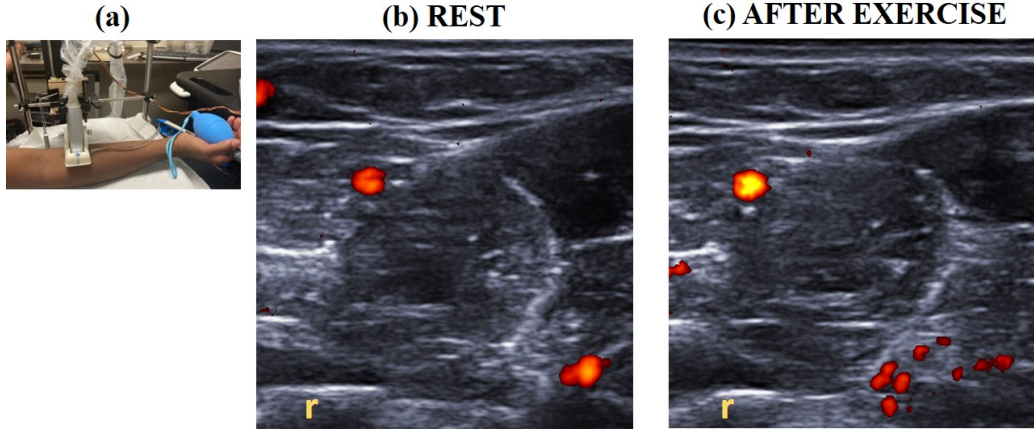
(a) Experimental setup for anterior forearm imaging; transducer is fixed in a grip claw and stabilization boot. A clench bulb shown in the subject's hand is used to perform light exercise. (b-c) The Power Doppler images of the anterior forearm in transverse view at rest (b) and after exercise (c). The radius is labeled with a yellow 'r'.
